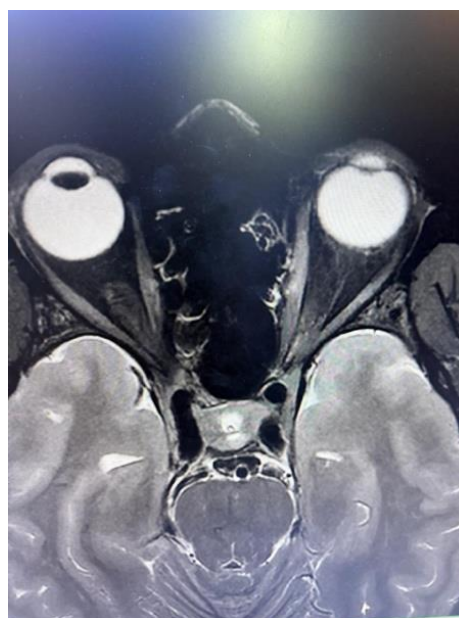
MRI showing peri optic neuritis with dural enhancement.
